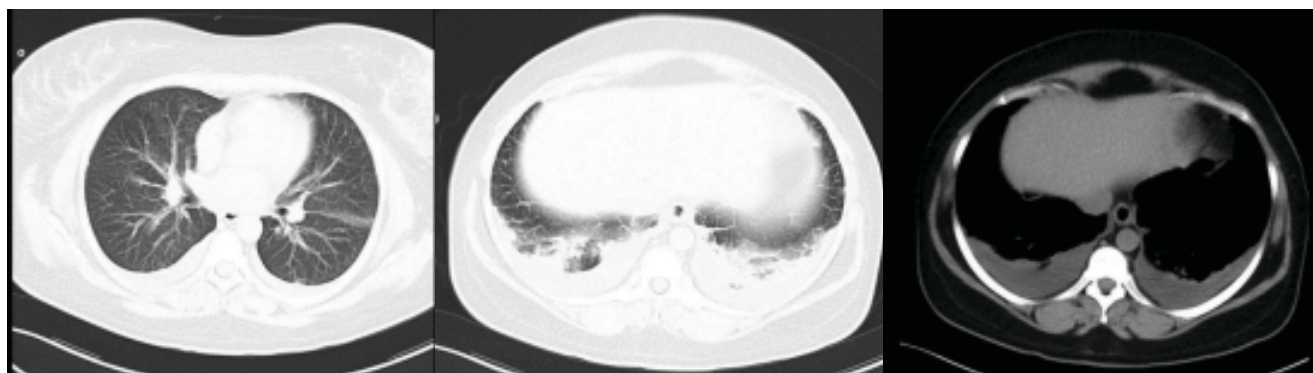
Preoperative pulmonary CTA
